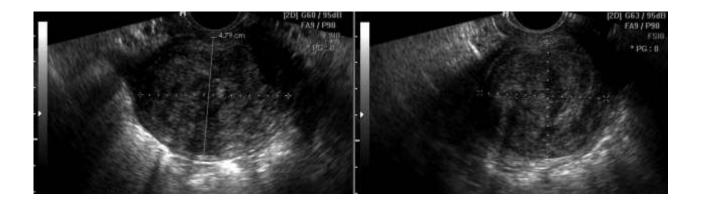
Fibroid - (www.ultrasound-image.com)
